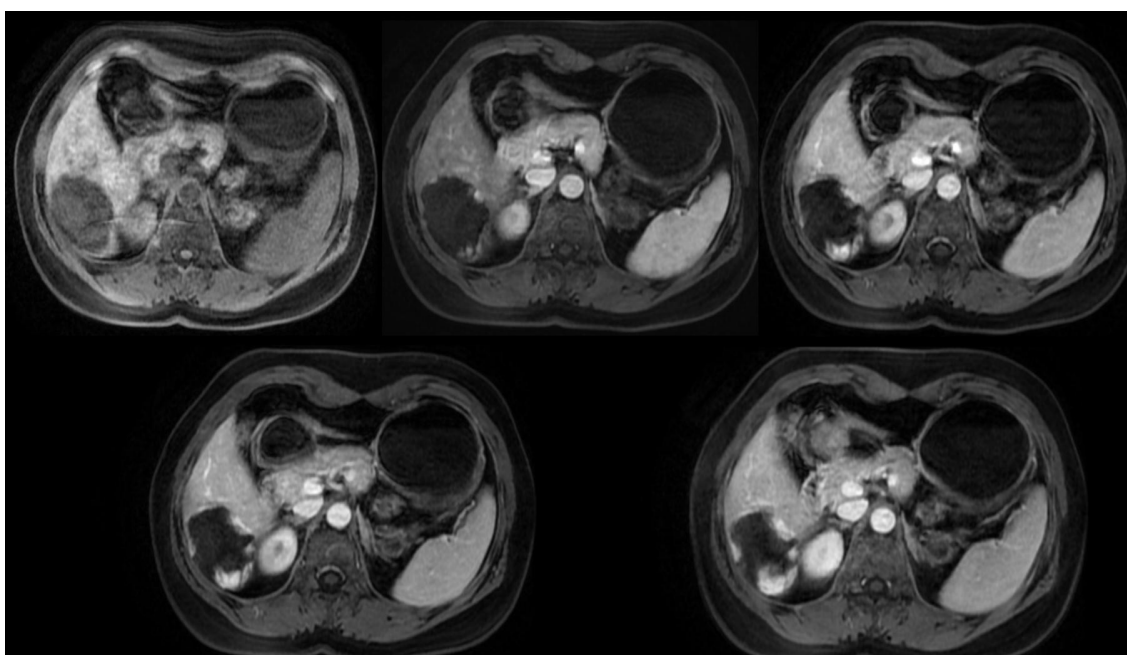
Axial T1-weighted MRI with contrast, multiphase study of a giant hepatic hemangioma. This image sequence demonstrates the gradual peripheral-to-central filling of the hemangioma, highlighting the characteristic enhancement pattern.
